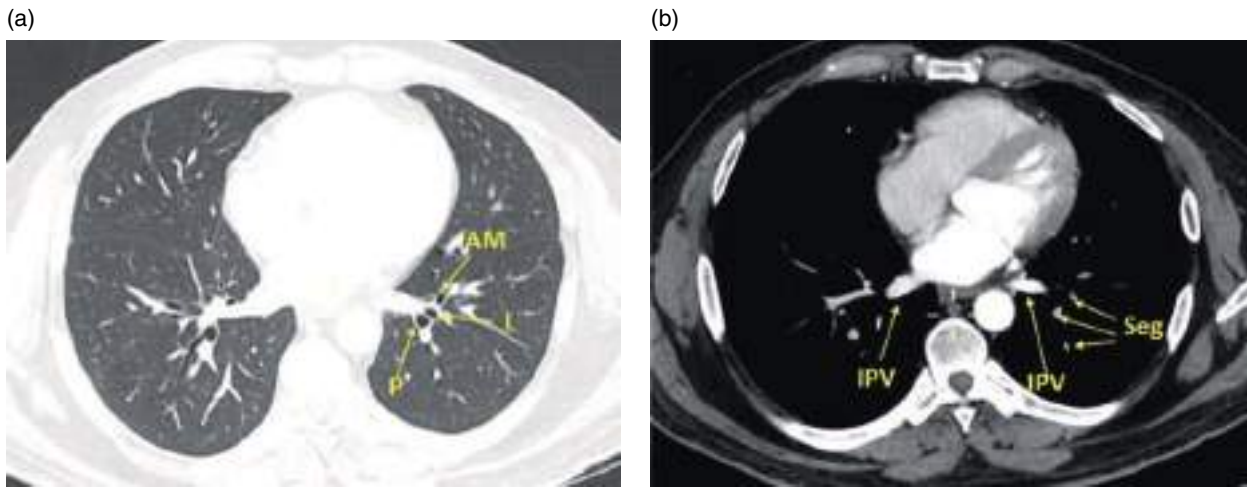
Basal segments of the left lower lobe. (a) Axial CT image (lung window). Basal segments in a clockwise direction are the anteromedial basal (AM), lateral basal (L), and posterior basal (P). (b) Axial CT image (mediastinal window). Seg, segmental arteries; IPV, inferior pulmonary veins.
